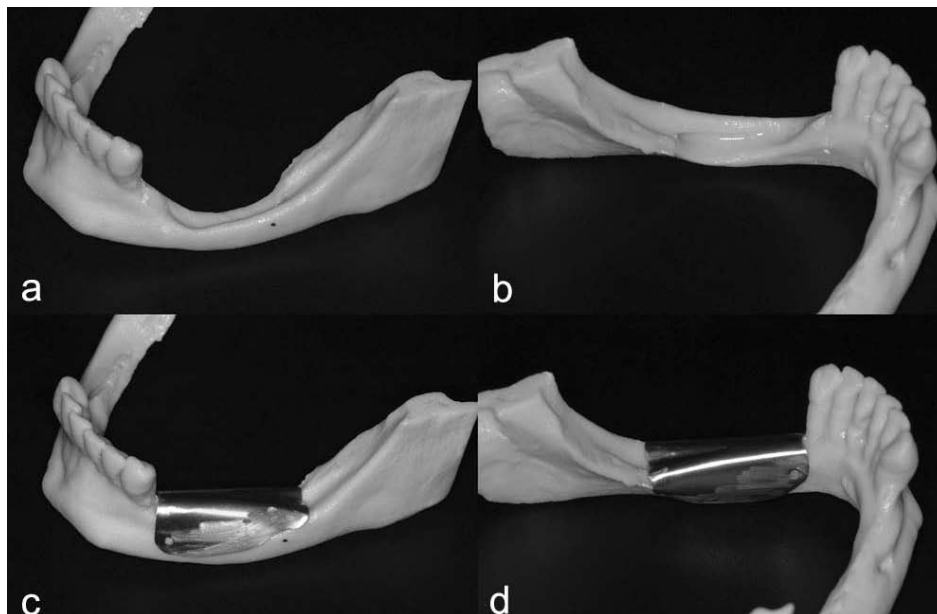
a, b) The stereolithographic model obtained from the Cone Beam Computerized Tomography of the patient; c, d) a pure titanium foil was moulded on the stereolithographic model. Two holes were performed in the anterior portion of the device for its stabilization via fixation screws.
